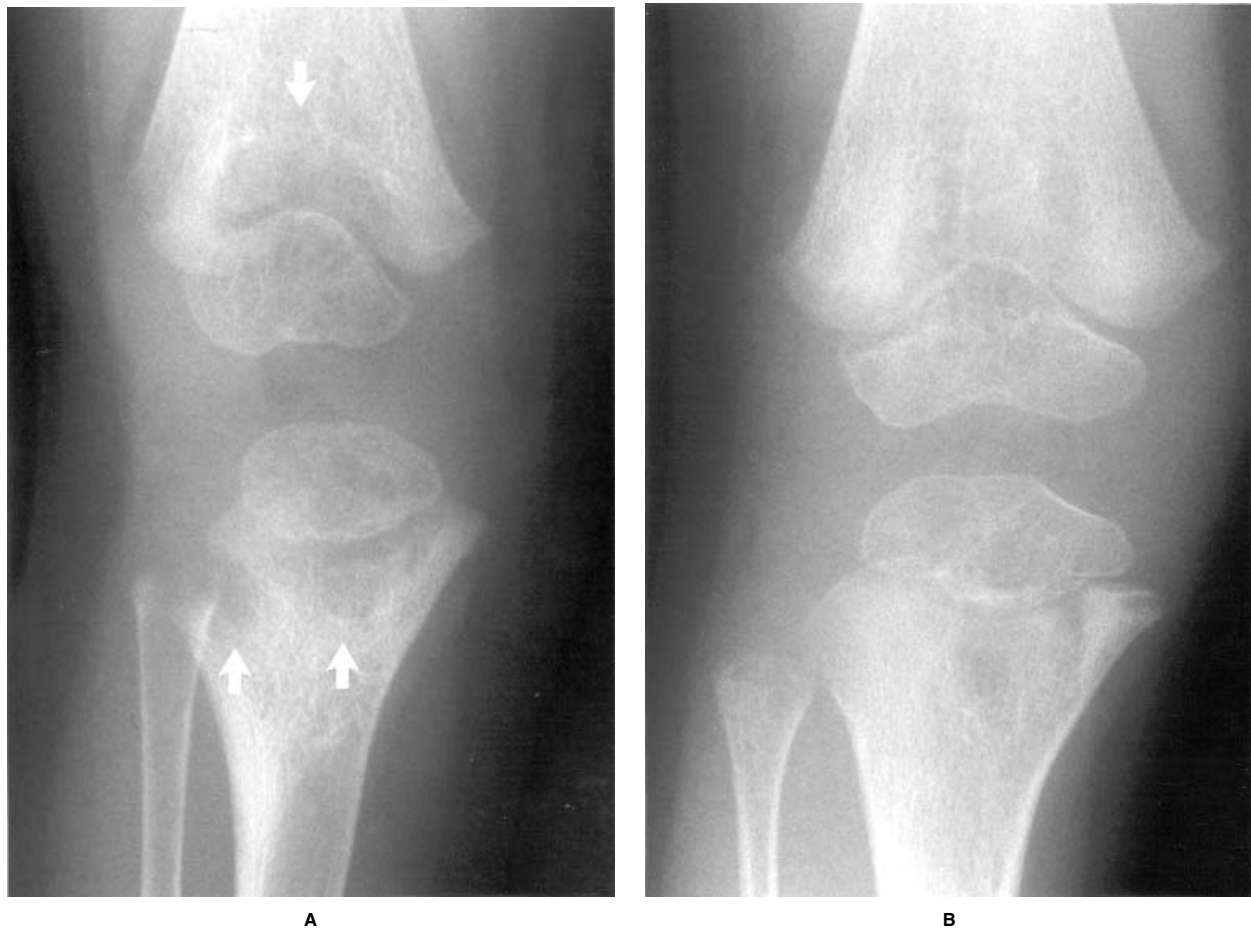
Hypophosphatasia. A) Pathognomonic “tongues” of radiolucency (arrows) project from physes into metaphyses in the knee of this 2-year-old boy with the infantile form of hypophosphatasia. This finding is especially noticeable in the proximal tibia. B) By age 3½ years, there has been considerable spontaneous radiographic improvement.
